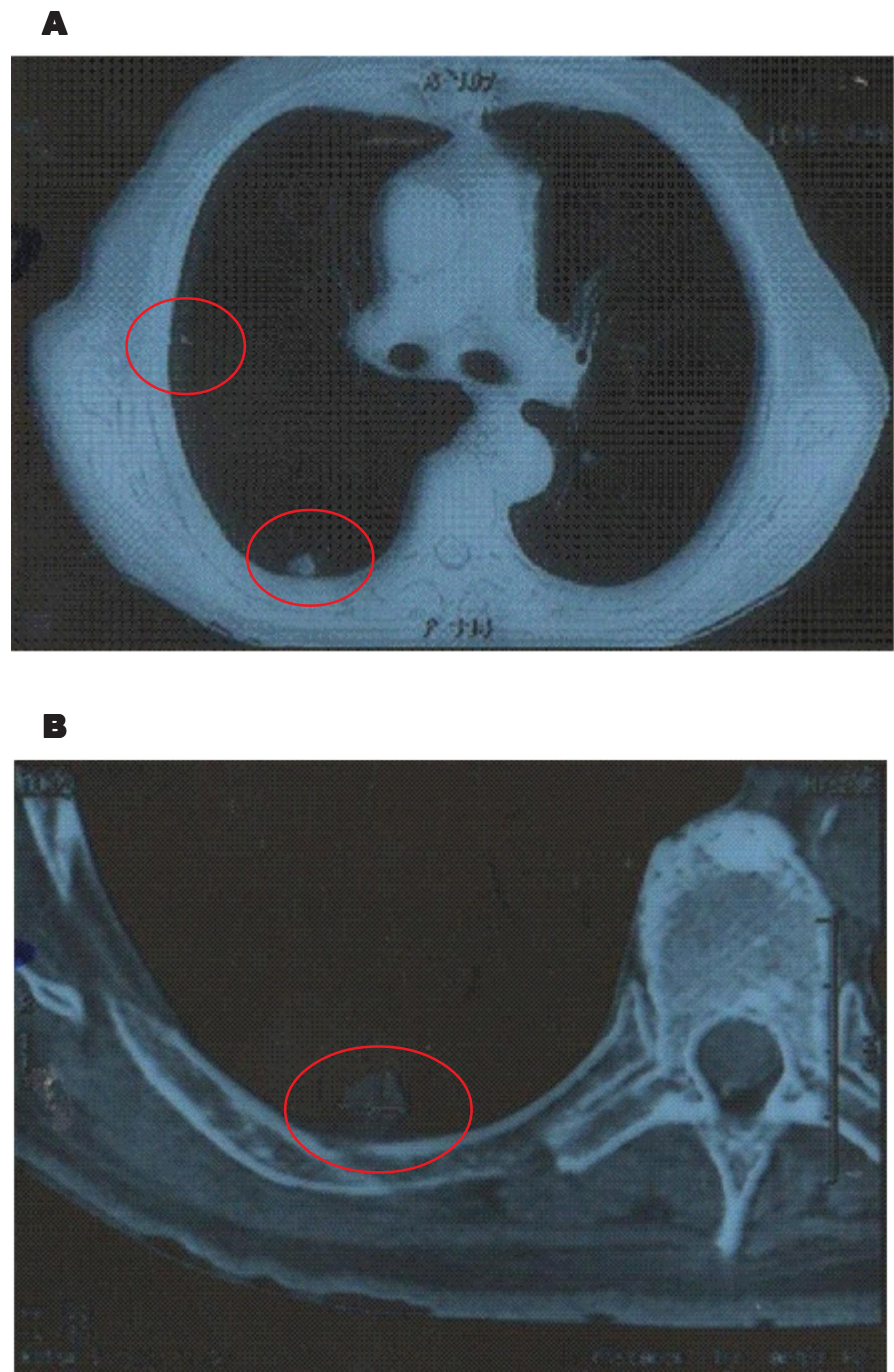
A, B: CT scan identified an nodules located in segments 3 and 6 of the right lung, suggesting secondary implants.
